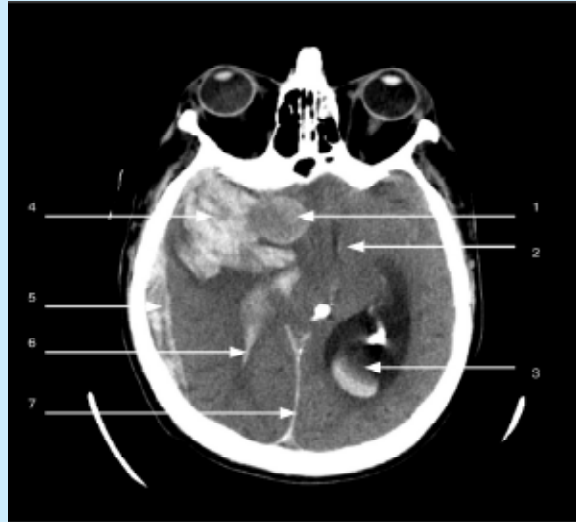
CT scan without iv-contrast obtained at admission about 1 hour post onset of symptoms.
